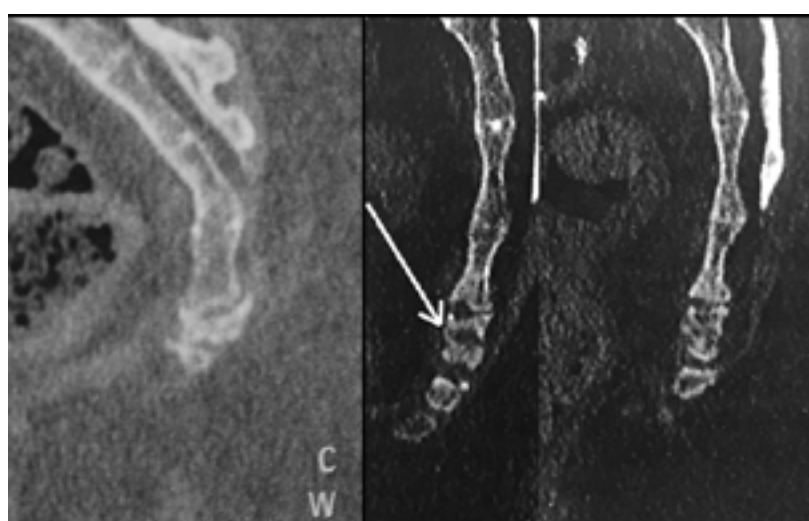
Two C1 fractures not visible on an x-ray, but only on a CT scan image.
